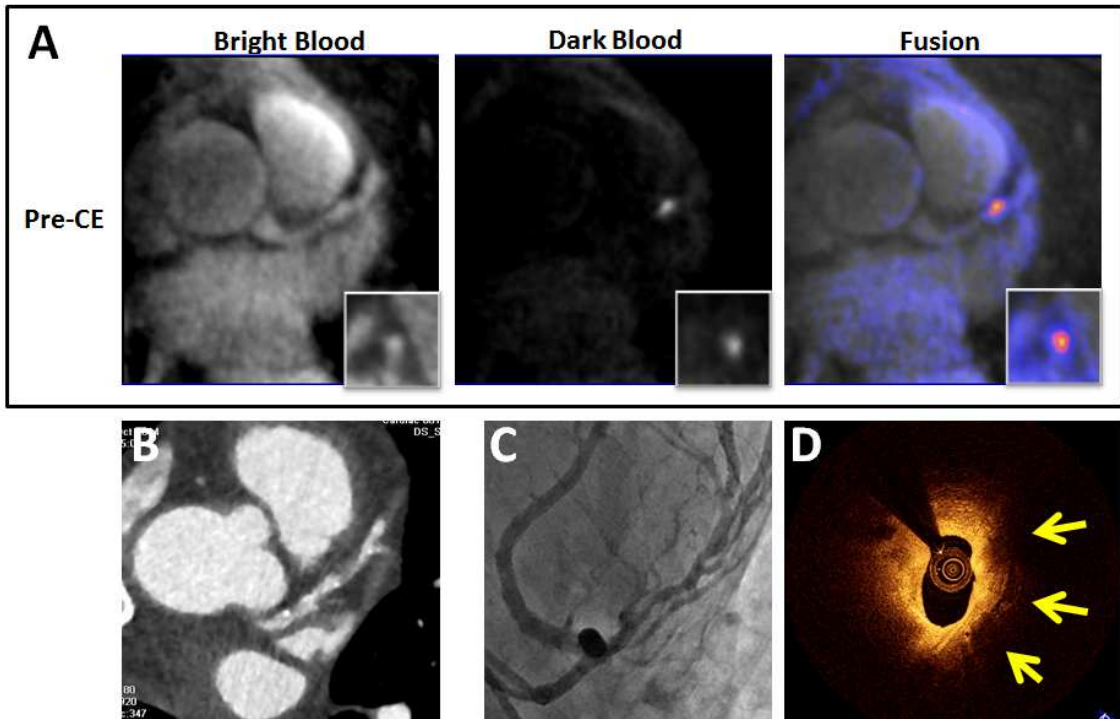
Representative case of a CAD patient with a HIP at middle LAD on pre-CE T1w MRI. A: Pre-CE dark-blood T1w images and bright-blood reference images. B: CT angiography. C: X-ray angiography. D: OCT cross-sectional image at the corresponding location of the HIP on MRI.
